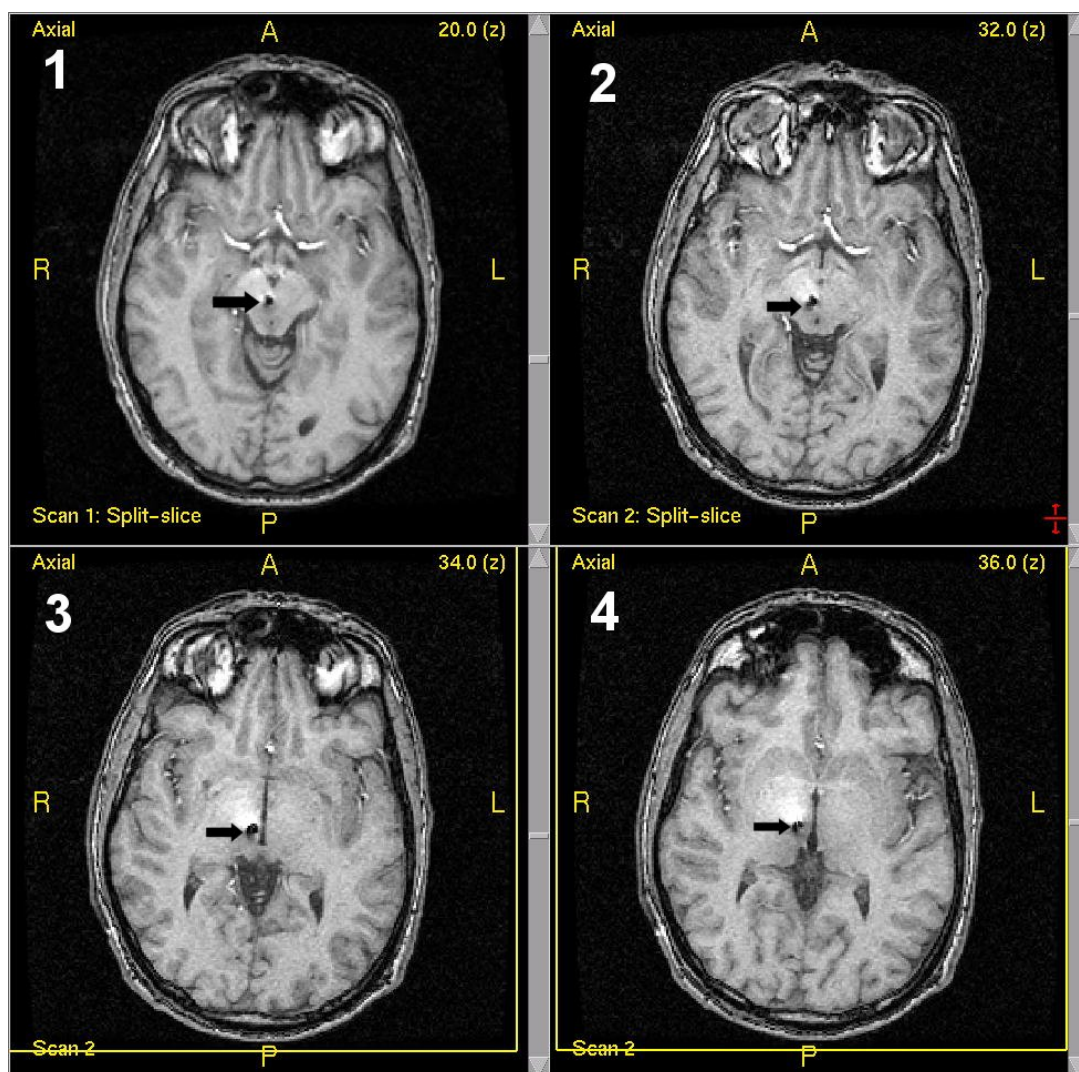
T-1 weighted axial MRI scan (2 mm, thickness, zero spacing) to confirm correct electrode placement.
